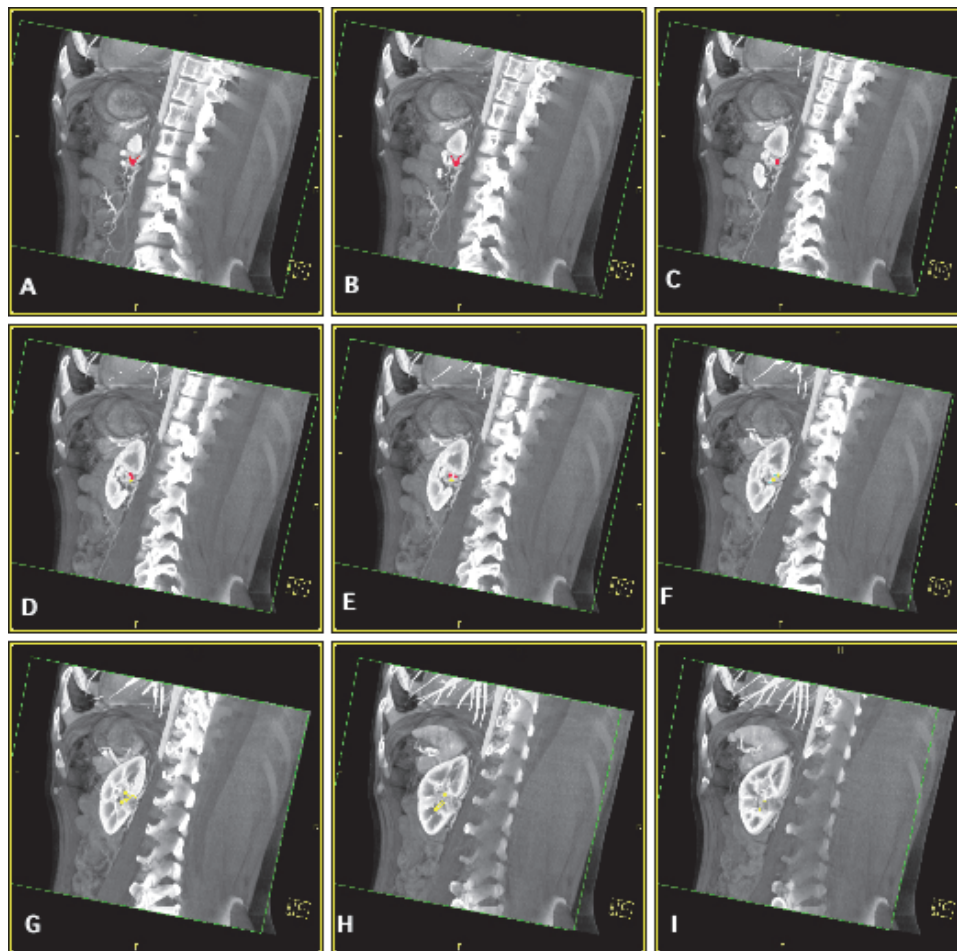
A left renal tumor very close to the renal hilum (Figure 3). Oblique view from the dorsal to ventral direction in the arterial phase. The CT scans are arranged from central (A) to lateral (I). A, B, C: An artery (red) branches off from a proximal vessel and run toward the periphery. D, E: The artery (red) divides into three small arteries (red, red, and yellow). F: The yellow artery divides into four arterioles (two yellow and two blue). G, H, I: The tumor can be seen in the midportion of the kidney. Two yellow arteries run close to the tumor (T) with a branching artery (green). During NSS, we should pay careful attention to this yellow artery that may feed the tumor.
